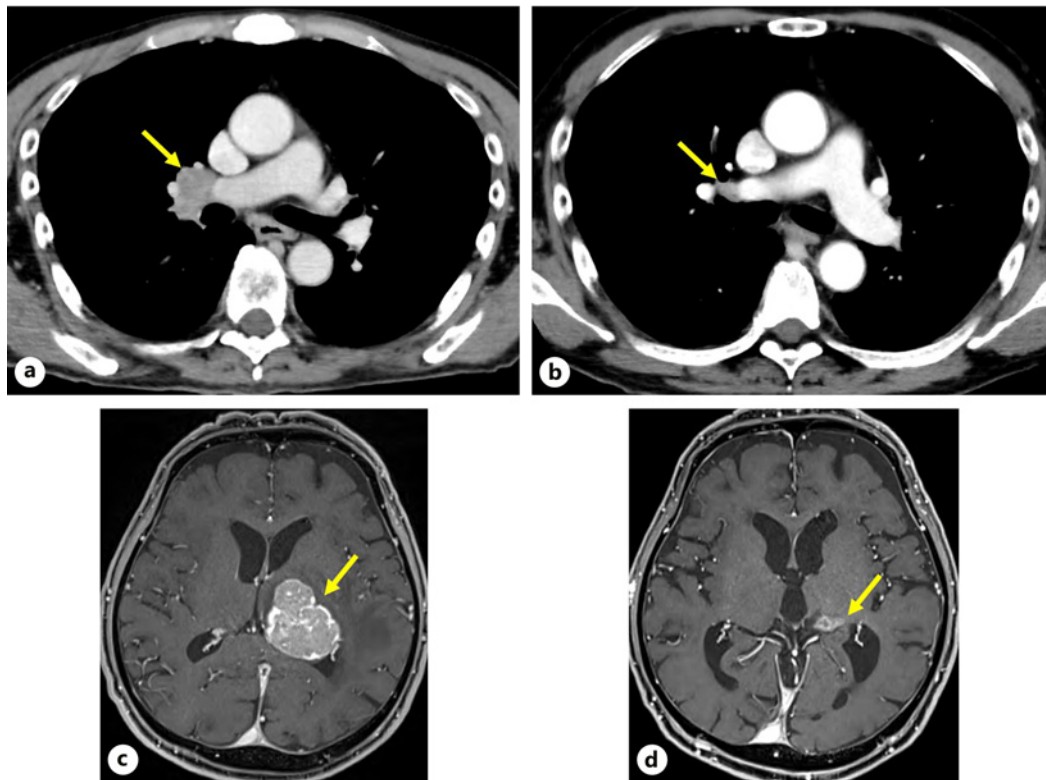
Comparison of images during the initial diagnosis and the appearance of anemia. a Primary tumor at initial diagnosis on contrast-enhanced CT. b Primary tumor during anemia on contrast-enhanced CT. c Brain metastases at initial diagnosis on head MRI. d Brain metastases during anemia on head MRI. MRI, magnetic resonance imaging; CT, computed tomography.
